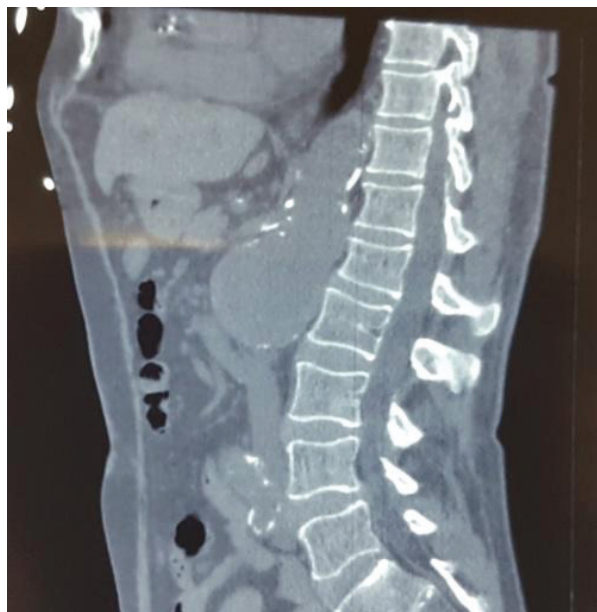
Multislice computed tomography angiography of suprarenal aneurysm, 9.5 cm x 8 cm, and previous reconstruction of abdominal aneurysm with Dacron N°XVIII tubular graft.
